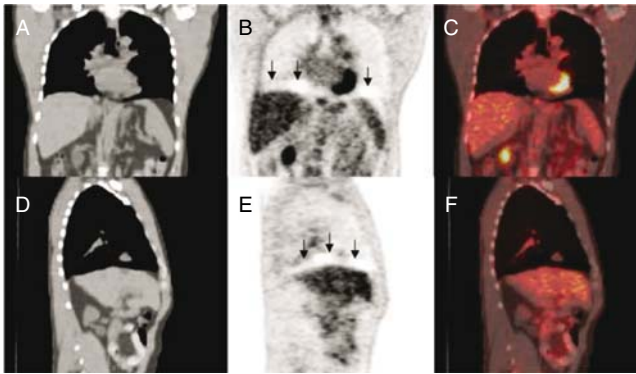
Demonstration of a cold artefact on PET images reconstructed with CT-based attenuation correction. (A) Coronal CT, (B) ^{18}F -FDG PET, and (C) fused, and (D) sagittal CT, (E) PET, and (F) fused images are displayed. A region of decreased metabolic activity is demonstrated in the diaphragmatic region (below vertical arrows), representing a “cold artefact”. Reprinted with permission from ref.¹¹⁰
